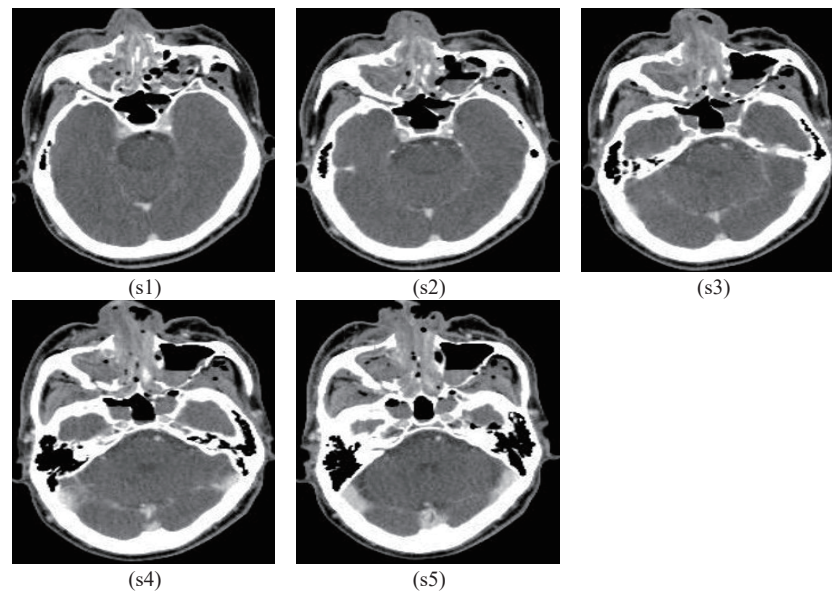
Sequential CT showing extravasation (marked with circles) within the facial trauma, where s_1, \dots, s_5 indicate slice #1, \dots , slice #5.
